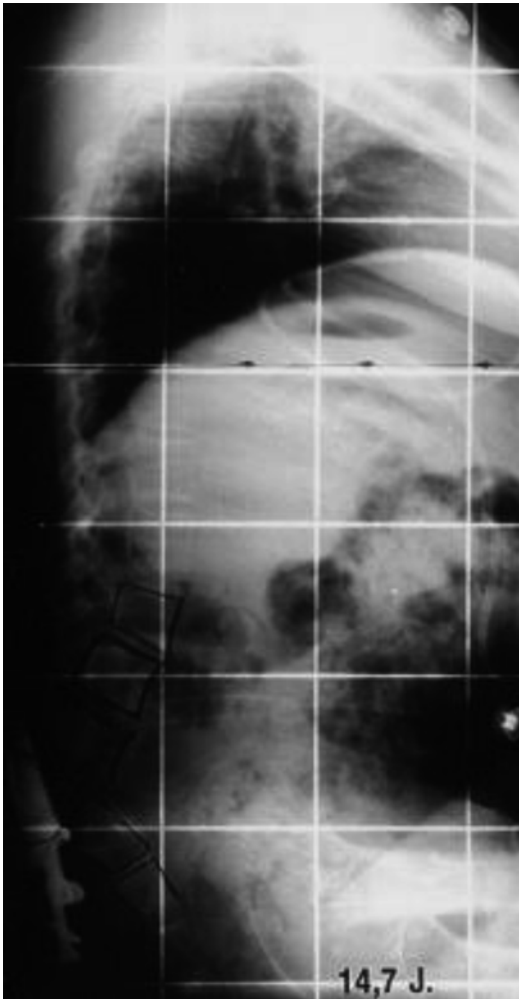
Lateral radiographs after correction of kyphotic deformity (Reprinted from Furderer et al. [7] with permission from Springer Science)
